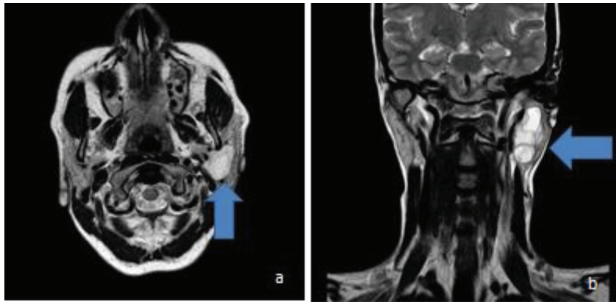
Magnetic resonance images. (a) T2WI axial section shows hyperintense lesion near external auditory meatus (vertical arrow). (b) T2WI coronal section shows the superoinferior extent of hyperintense lesion with well-defined outline (horizontal arrow).
